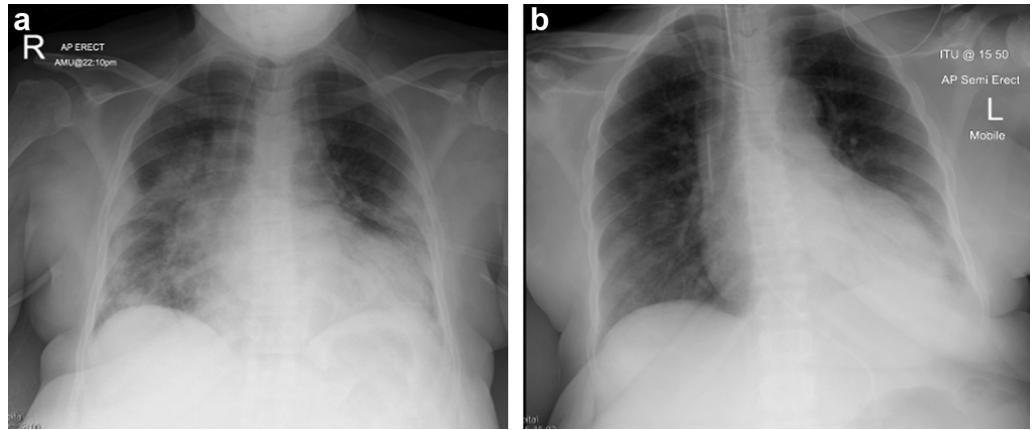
Case 2: Chest X-ray (a) on admission showing bilateral patchy consolidation and (b) 8 days later showing improvement in lung infiltrates.
